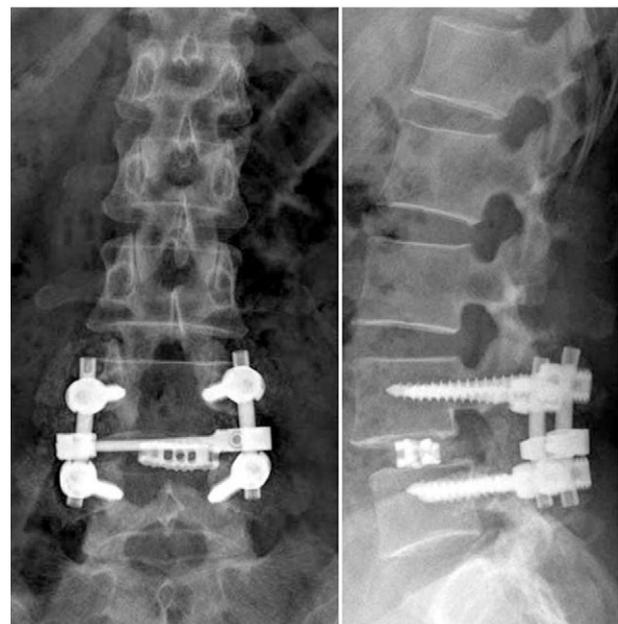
The postoperative plain radiographs show a successful L4 wide laminectomy and transforaminal lumbar interbody fusion of L4-5 in a patient with lumbar degenerative spondylolisthesis. (Image provided courtesy of Asian Spine Journal. From Sakai T, Sairyo K, Bhatia NN, et al. MRI changes of the spinal subdural space after lumbar spine surgeries: report of two cases. *Asian Spine J.* 2011;5(4):262-266.)
